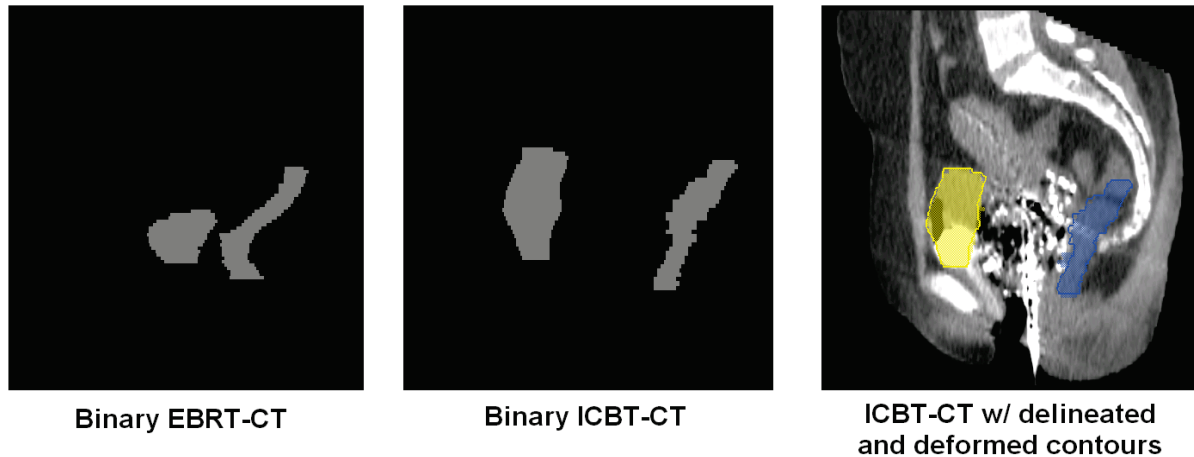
Example of binary EBRT-CT and binary ICBT-CT generated based on radiation oncologist drawn contours. The image on the right shows binary deformed contours (colorwash) mapped onto the ICBT-CT image. One can see that compared to using image intensities alone (Figure 16), both deformed bladder (yellow) and rectum (blue) contours agreed very well with their delineated counterparts.
